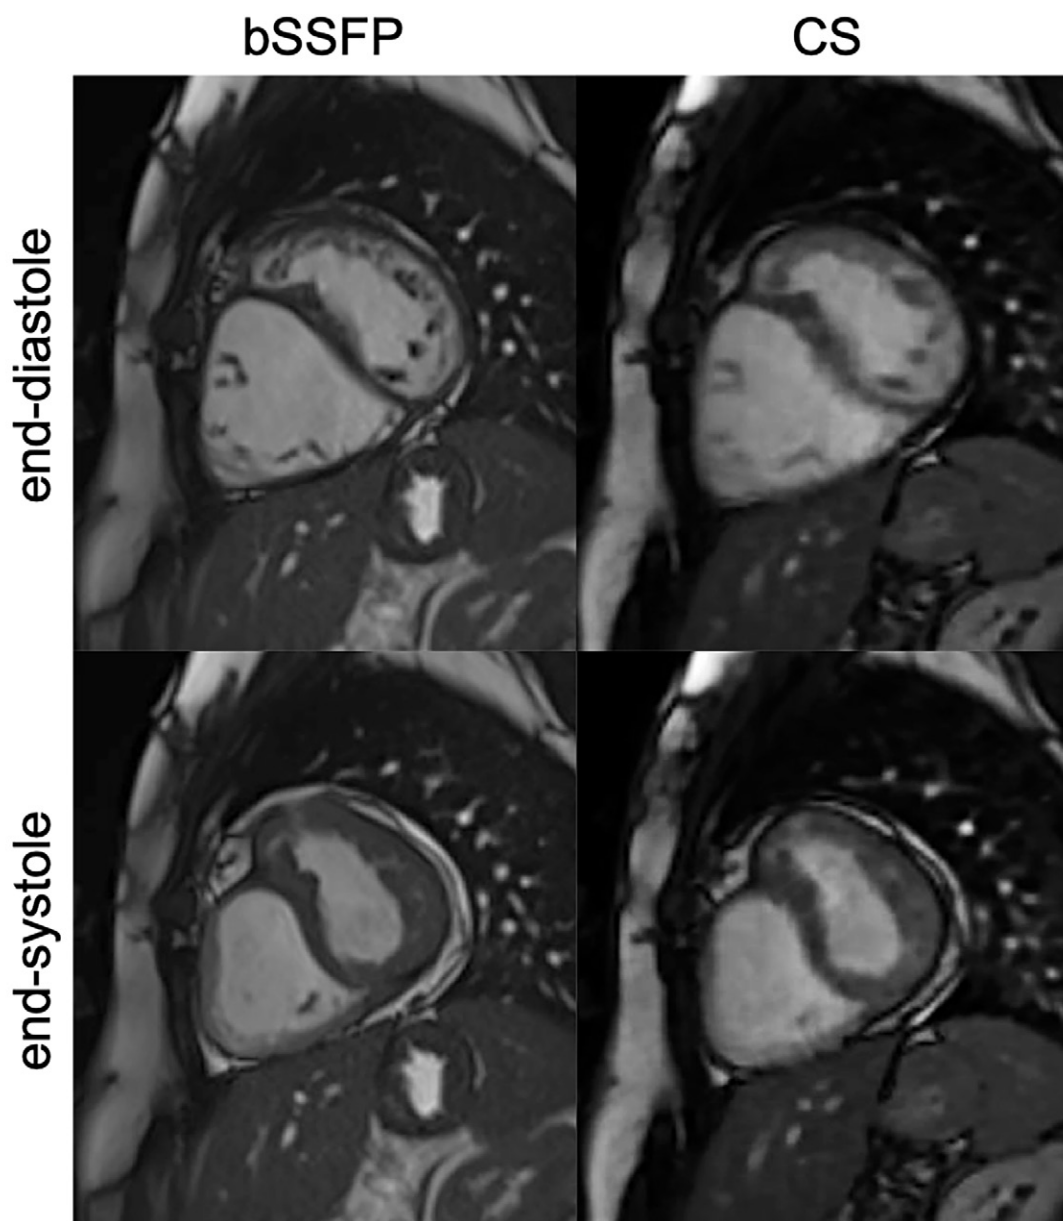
End-diastolic (top row) and end-systolic (bottom row) midventricular short-axis frames of standard bSSFP (left column) and real-time CS (right column) cine MRI sequences in a 15-year-old female patient with congenitally corrected transposition of the great arteries. The anterior chamber is the subpulmonary left ventricle, which is dilated due to the presence of an ostium secundum interatrial defect (not shown), whereas the posterior chamber is the hypertrophic systemic right ventricle. bSSFP = balanced steady-state free precession, CS = compressed sensing.
